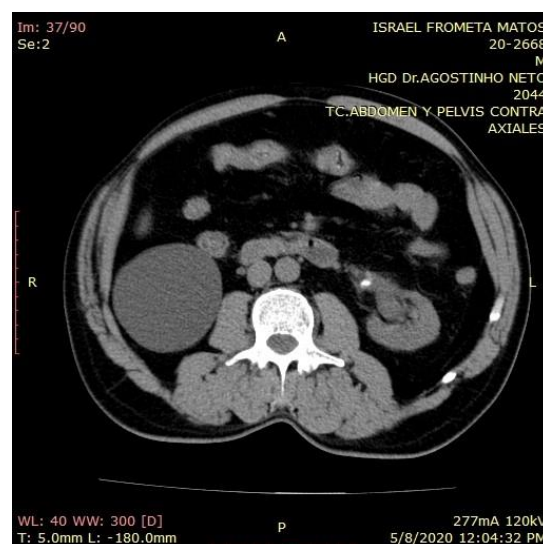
Axial view of the renal CT scan showing the location, size and repercussion of the lithiasis in the upper renal excretory tract
